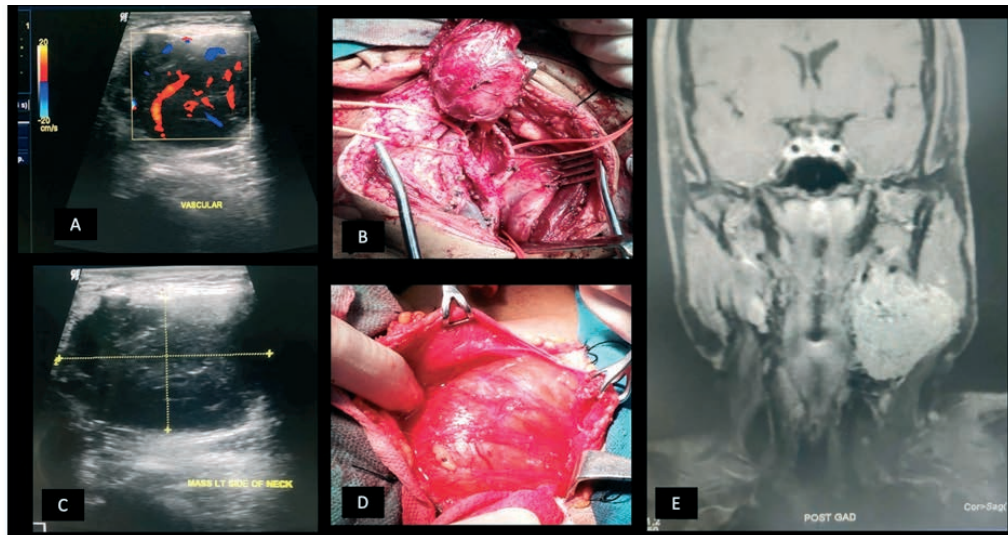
Investigation and operative pictures: A – vascular doppler neck mass – carotid body tumour; B – intra-operative image of carotid body tumour; C – ultrasonography neck showing cystic hygroma; D – intra-operative image of neck nymphangioma; E – MRI right sided carotid body tumour.
